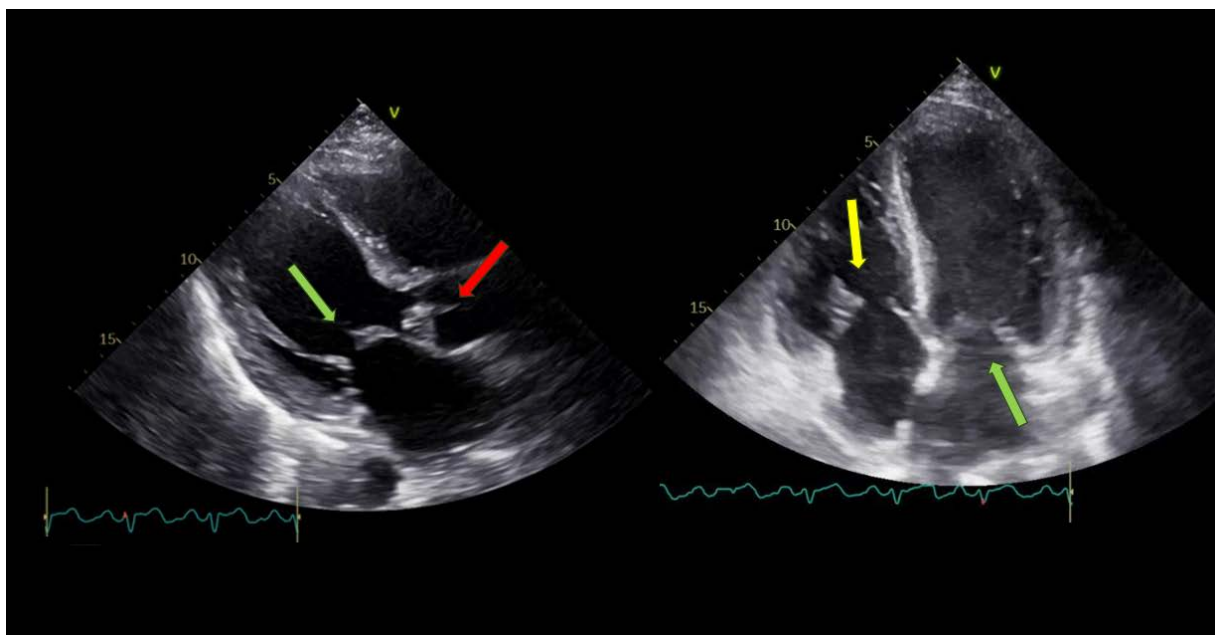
B. 2D transthoracic echocardiography: mitral (green arrow), aortic (red arrow) and tricuspid (yellow arrow) valves with visible vegetations in the course of infective endocarditis;
